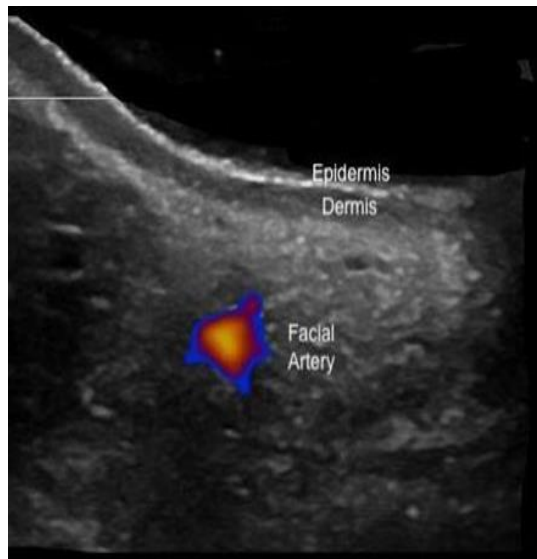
The high-resolution ultrasound image in the axial plane confirms the presence of a pulsatile, non-compressible vascular structure corresponding to the facial artery.
